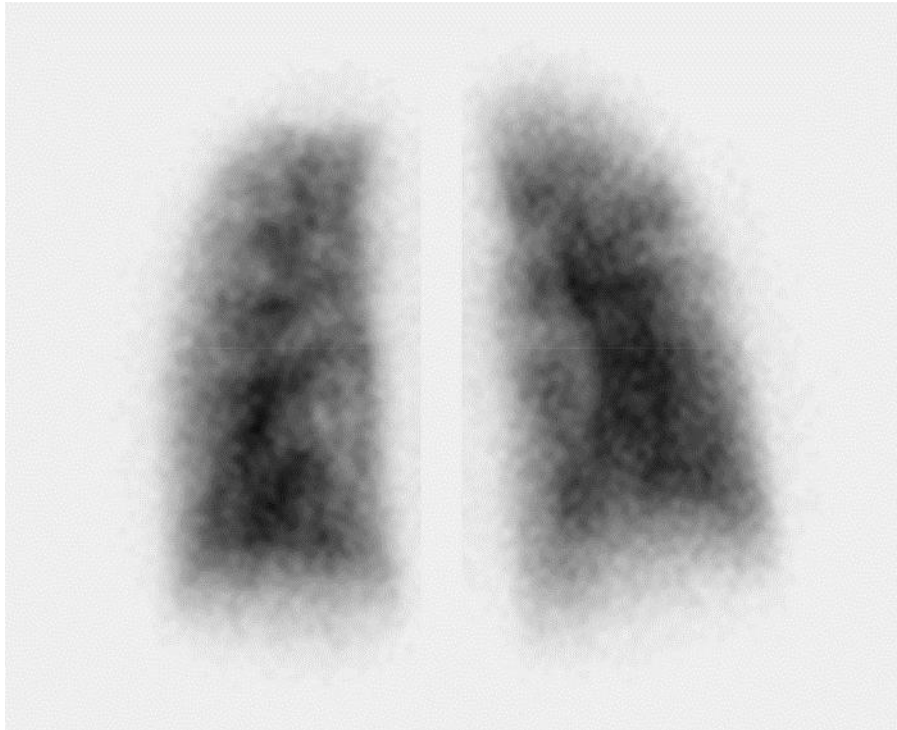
Perfusion lung scintigraphy showed multiple small peripheral perfusion defects in both lungs.
